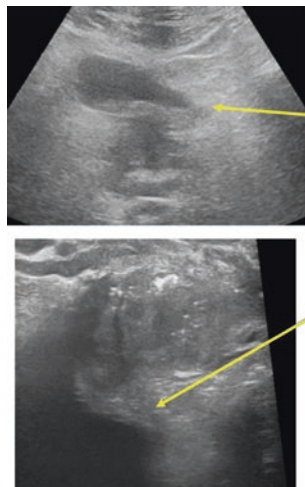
An infiltrating bladder tumor at the bladder neck. At transverse abdominal US, due to tumor's side and reduced bladder filling, the ultrasound appearance of tumor is confusing. At linear transrectal US, bladder tumor is easily identified and distinctive from the normal prostate
